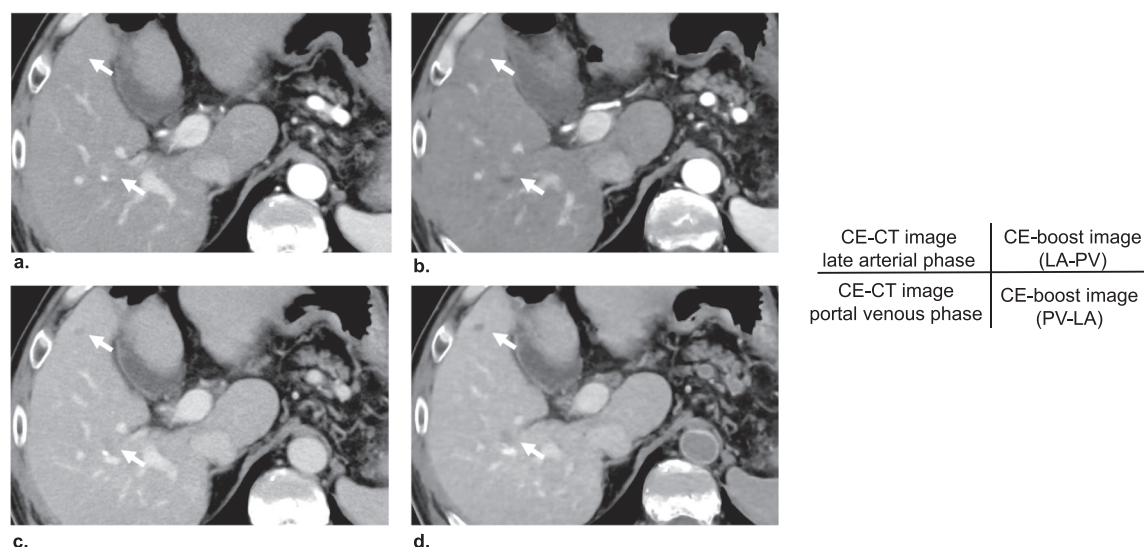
HCCs (arrows) in a 57-year-old man. (a) LAP image, (b) CE-boost (LA-PV) image, (c) PVP image, and (d) CE-boost (PV-LA) image. Each lesion has faint arterial phase enhancement and washout on the conventional CE-CT images (a, c). Corresponding CE-boost images demonstrate increased conspicuity of the lesions (b, d). HCC, hepatocellular carcinoma; LAP, late arterial phase; CE-boost, contrast enhancement boost; LA-PV, PVP subtracted from LAP; PVP, portal venous phase; PV-LA, LAP subtracted from PVP; CE-CT, contrast-enhanced CT.
